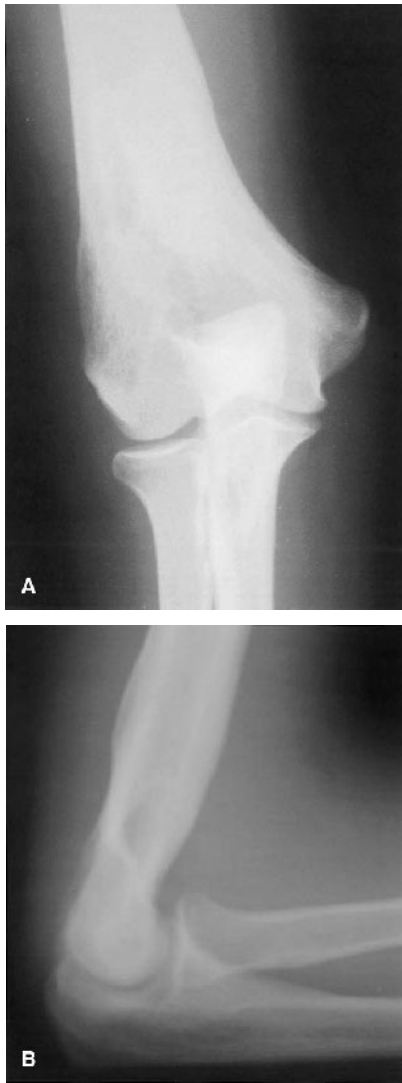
Anteroposterior (A) and lateral (B) radiographs at the latest follow-up.
